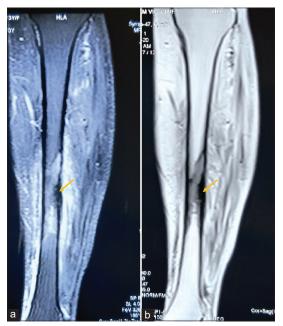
A 73-year-old female with a history of carcinoma breast, experiencing pain in the left leg since 1 year. (a an b) Coronal STIR and T1-weighted MR imaging performed in a different hospital shows focal intracortical area of low signal with adjacent intramedullary bone marrow edema in mid-tibial shaft and surrounding soft-tissue edema. MRI report suggested the possibility of osteomyelitis or stress fracture. Bone biopsy was performed in our hospital and report came as metastasis from carcinoma of breast.
